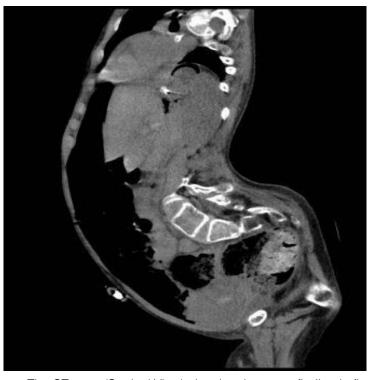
The CT scan (Sagittal View) showing the same finding in figure 3
